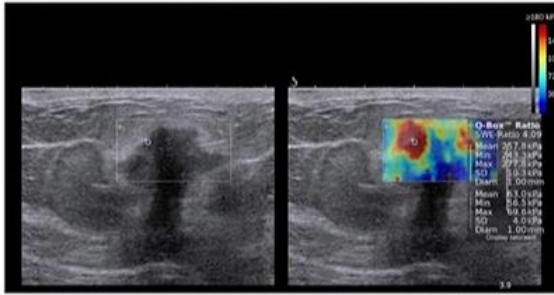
Figure from Sigrist, R.M.S., Liau, J., Kaffas, A.E., Chammas, M.C., Willmann, J.K. (2017). Ultrasound Elastography: Review of Techniques and Clinical Applications. *Theranostics*, 7(5), 1303-1329. <https://doi.org/10.7155/thno.18650>
